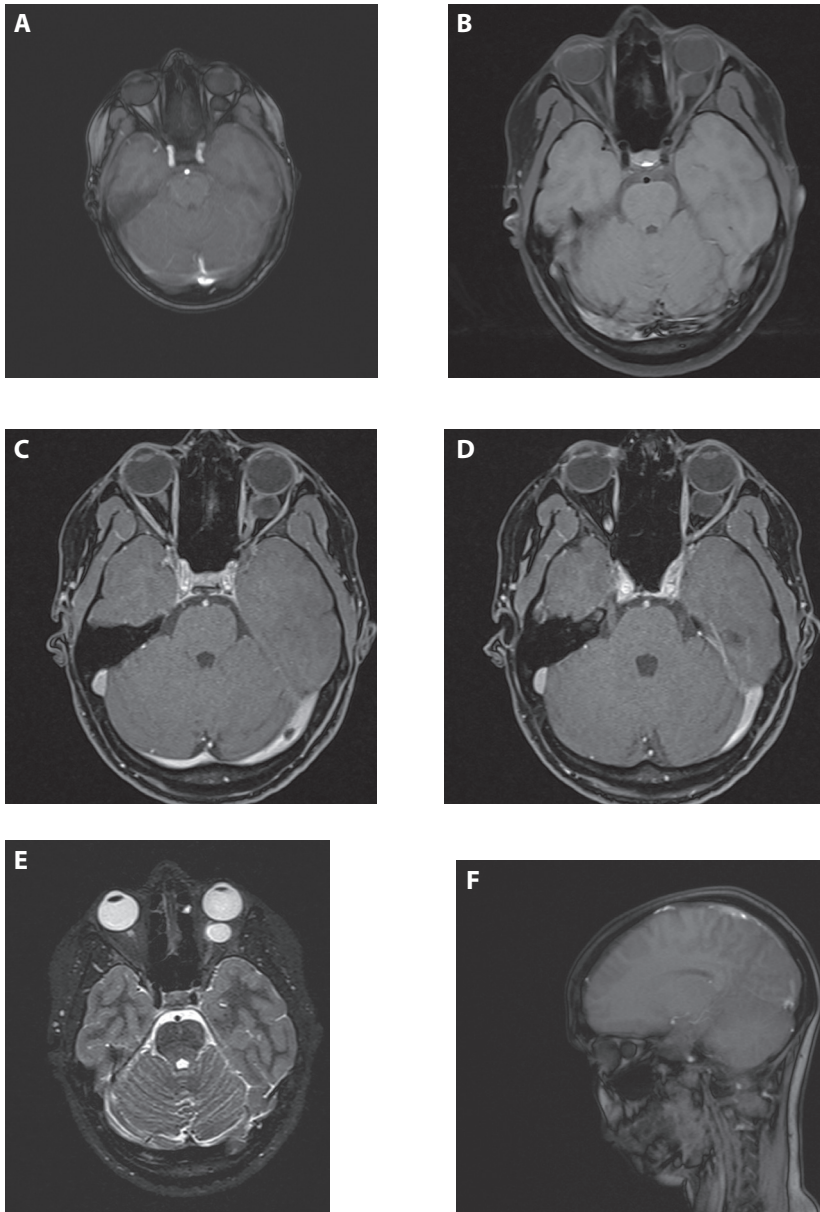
Preoperative axial MRI scans of the patient. (A) Arachnoid cyst of the left optic nerve. (B) MRI shows enlargement of the left optic nerve. (C) More details about the enlargement of the optic nerve because of the cyst. (D) The whole extension of the cyst. (E) MRI with contrast.
